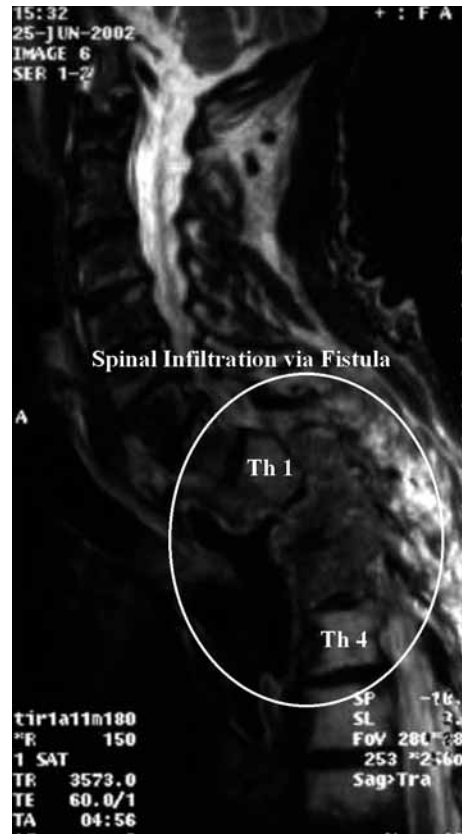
MRI : tumour infiltration of the spine
